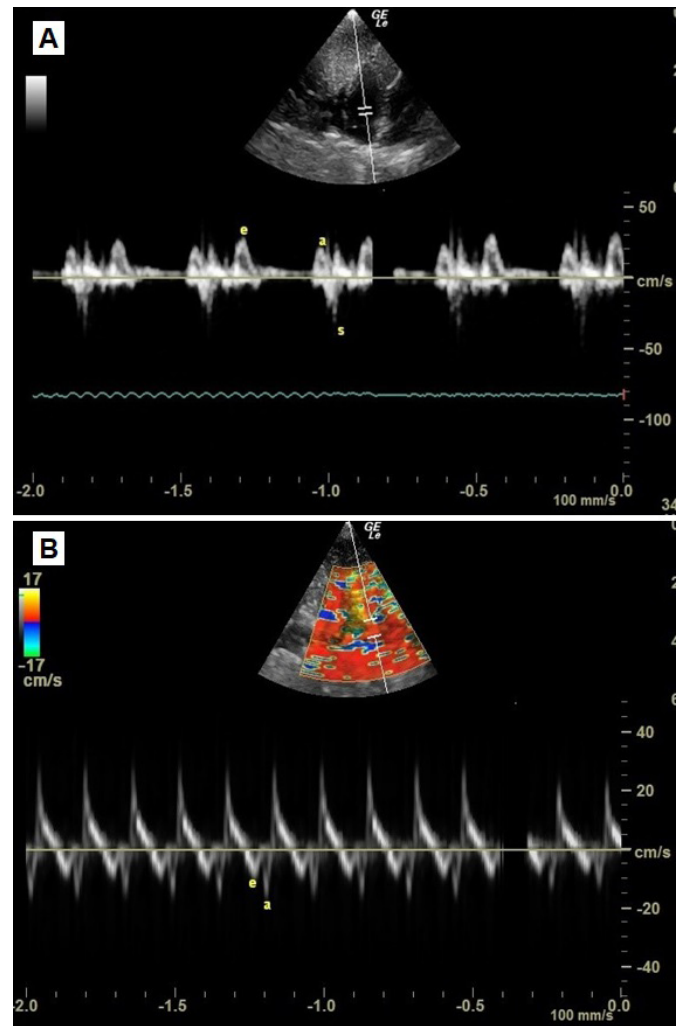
Left atrioventricular flow obtained with pulsed Doppler (A) and tissue Doppler (B) using the horizontal ventromedian approach in the *Amazona aestiva* subjected to chemical restraint with midazolam (0.2 mg/kg) associated with ketamine (25 mg/kg) (PMK protocol) shows the standard E < A pattern.
